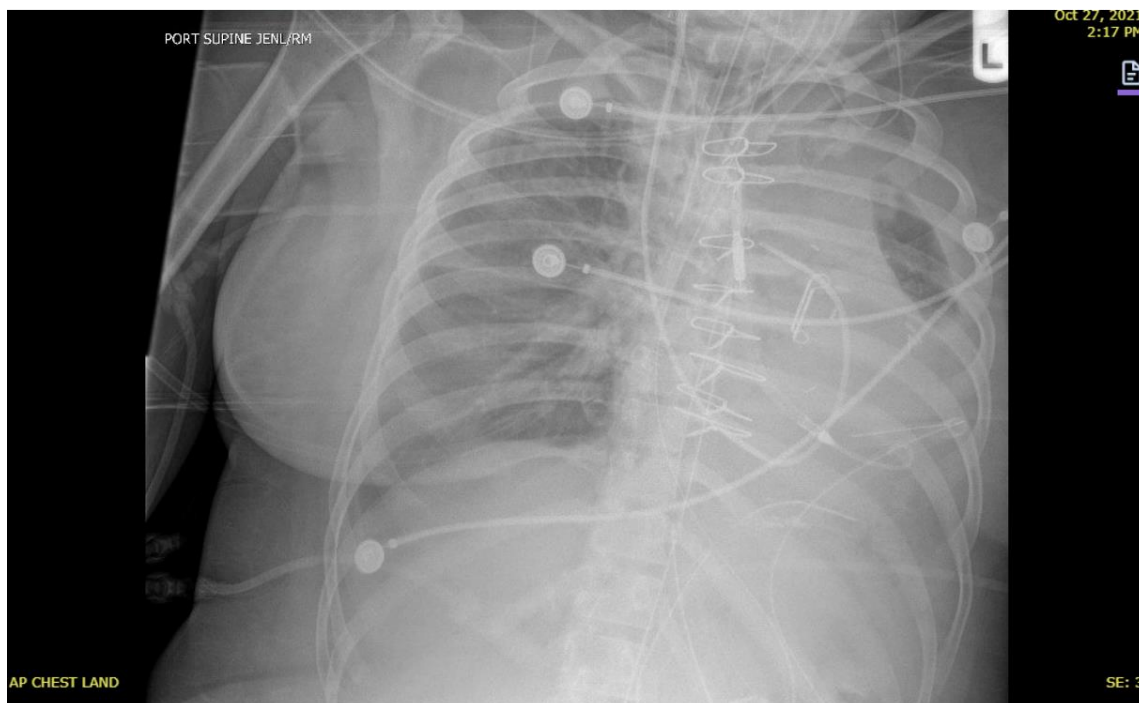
Admission chest x-ray. Chest x-ray demonstrating mediastinal widening, enlarged cardiac silhouette, and blunting of the left costophrenic angle prior to evacuation of hemo-pericardium and hemothorax.
